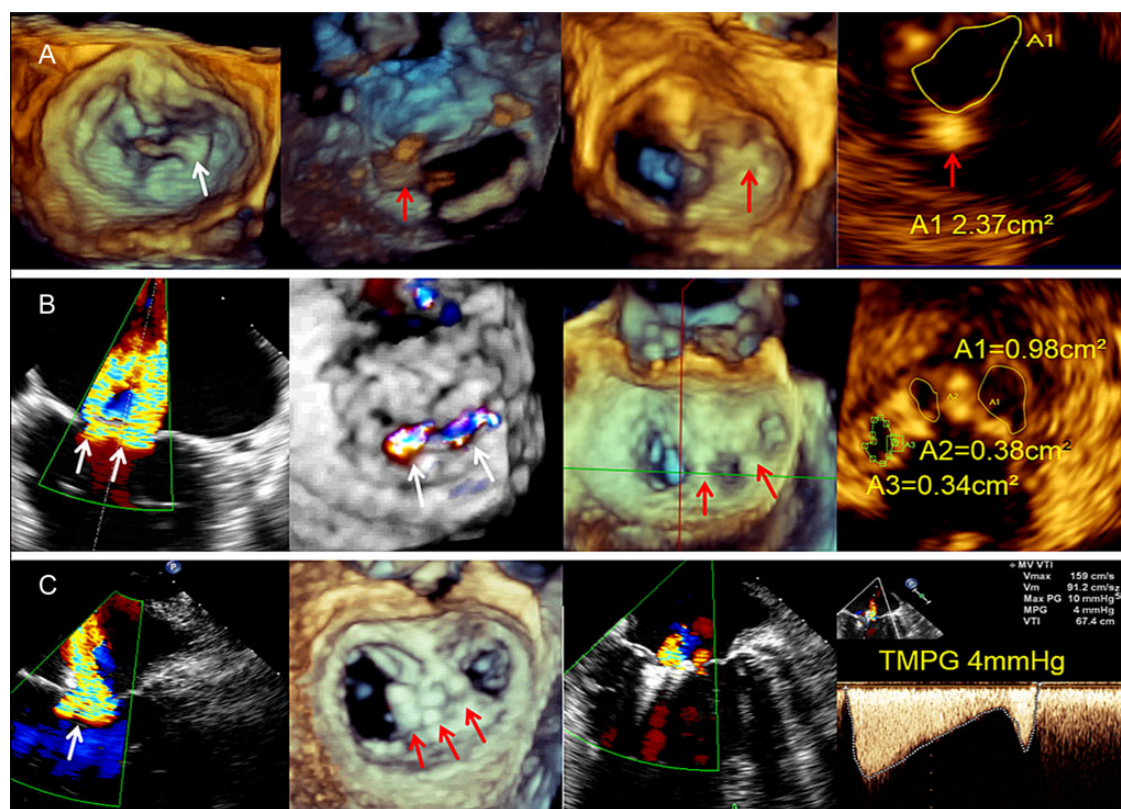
Specific case examples. (A) A case with a P3 prolapse is shown. The pathology can be identified in a 3D LA enface view in the first image on the left side (the prolapse is marked with a white arrow). The second image on the left shows the Clip (red arrow) in medial position from the LV side in a 3D view. The third image shows the newly created geometry of the MV with a single lateral orifice from the LA side. The tissue bridge in the medial part of the MV is marked with a red arrow. 3D planimetry (Qlab software, Philips) of the single orifice is seen in the image on the right side. The position of the Clip is marked with a red arrow. (B) A case with two large jets medial and lateral in the central segment is shown. The image on the left shows an intercommissural view at 60°. The two jets are marked with white arrows. In the second image on the left an LA aspect of the MV is seen in a 3D enface view with colour Doppler. The origin of the two jets is marked with white arrows. The third image shows the result after placement of two Clips in the target regions in a 3D LA enface view. This resulted in a triple orifice MV. In the image on the right-side planimetry of the three orifices is demonstrated (Qlab software; Philips). The total MVA is 1.7 cm² in this case. The mean TMPG was 5 mmHg (not shown) which was borderline, but acceptable. (C) A case with functional MR is demonstrated. A broad jet in the central part of the MV can be seen in an intercommissural 2D TEE view in the first image on the left side. The Vena contracta width was 12 mm in this case (not shown). After placement of three Clips in the central part of the MV which can be seen in the second image on the left side (3D LA enface view; each red arrow marks the position of one Clip), residual MR was considered to be mild as shown in the third image from the left in an intercommissural 2D TEE view at 65°. The TMPG after positioning of the third Clip was acceptable (4 mmHg) as shown in the image on the right side. LA, left atrium; LV, left ventricle; MV, mitral valve; MR, mitral regurgitation; 2-/3D, two-/three-dimensional; TMPG, transvalvular mean pressure gradient; MVA, mitral valve area.
